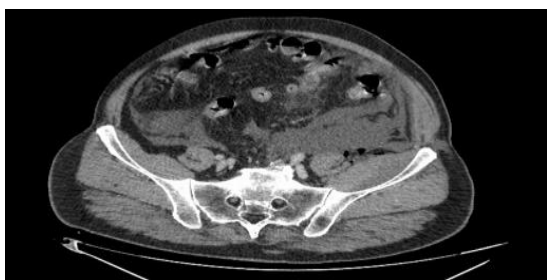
CT images - cross section with free gas: Pelvis.
